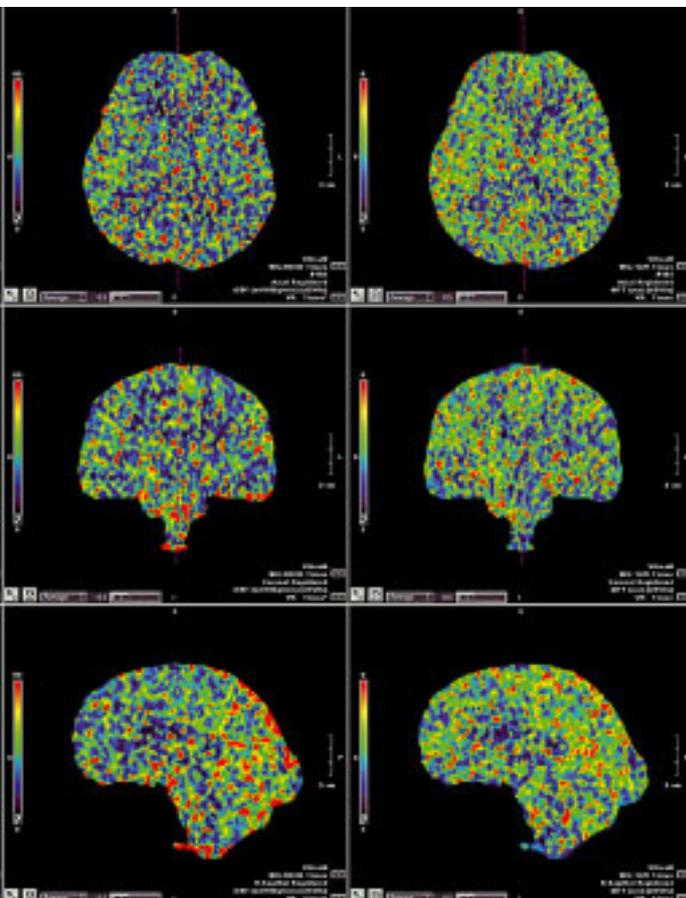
Generation of CT perfusion maps with the Vitrea 4.0 software (Vital Images, Minnesota, USA). The resolution of 0.5 mm along the z-axis allows for multiplanar reformation of the whole-brain perfusion maps without loss of information.
